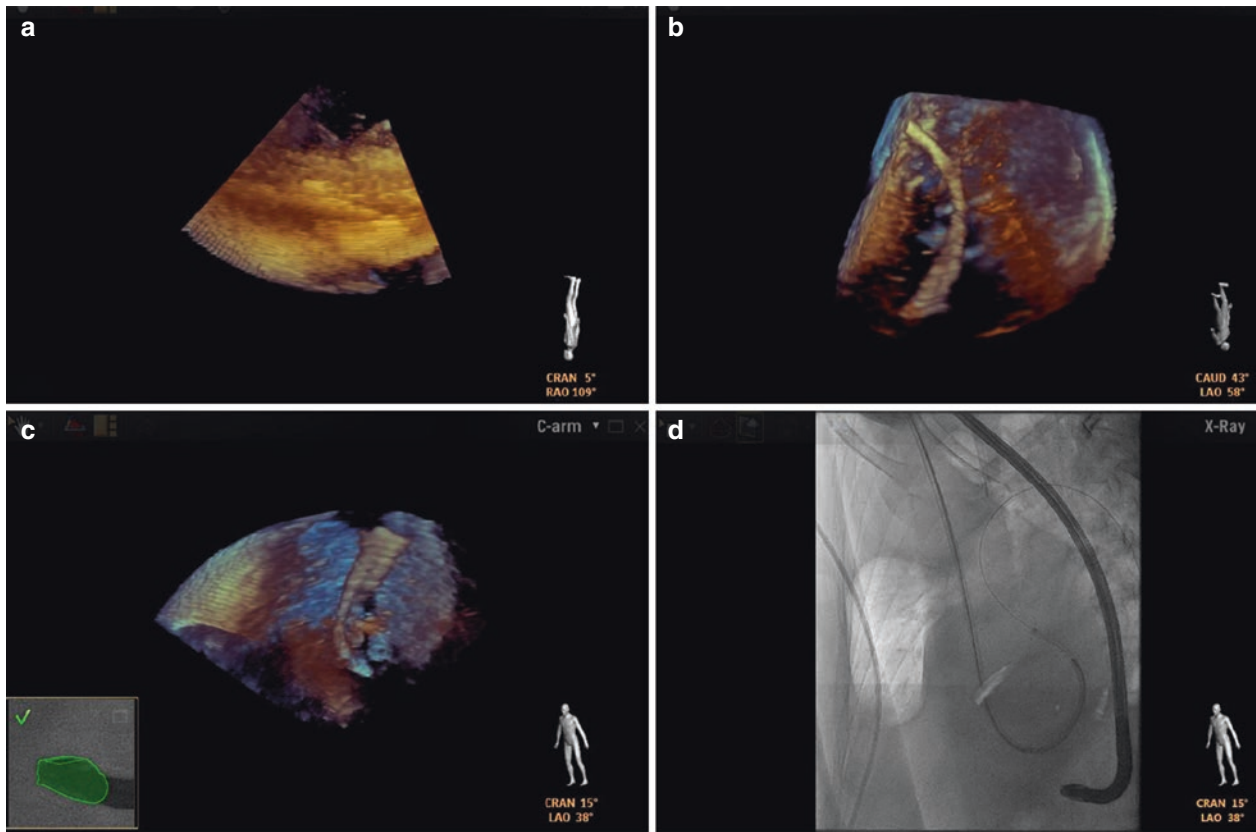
Echo-fluoroscopy fusion—advancing VSD closure device. Different views of the 3D TEE are shown. (a) The “free view” allows the operator to cut the 3D reconstructed volume and perform 360° rotation. (b) This view allows the echocardiographer to perform additional review. (c) This view coincides with the position of TEE
